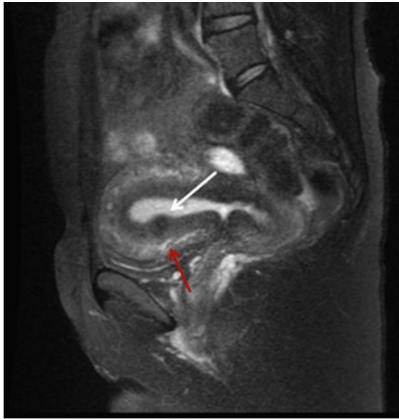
T2 pelvic MRI showing submucosal fibroid (white arrow) and areas of adenomyotic tissue at the thickened junctional zone (red arrow).
